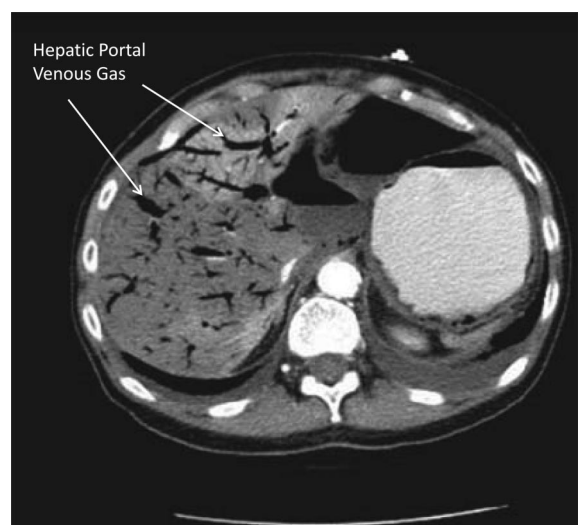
CT scan demonstrating hepatic portal venous gas (arrows) in a patient with pneumatosis intestinalis.
